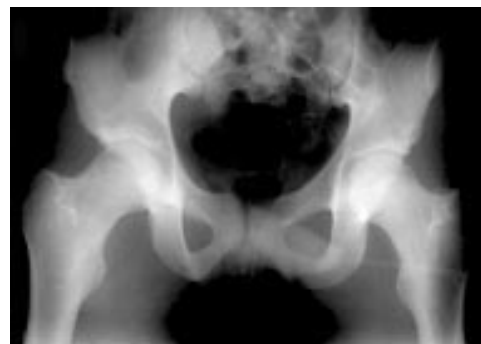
Radiograph of the pelvis after manipulation showing concentric reduction and excluded any intra-articular fragments.
